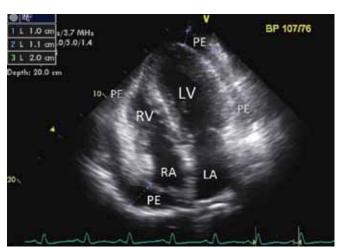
Echocardiogram in apical 4-chamber window shows circumferential pericardial effusion. PE: pericardial effusion; RA: right atrium; RV: right ventricle; LA: left atrium; LV: left ventricle
